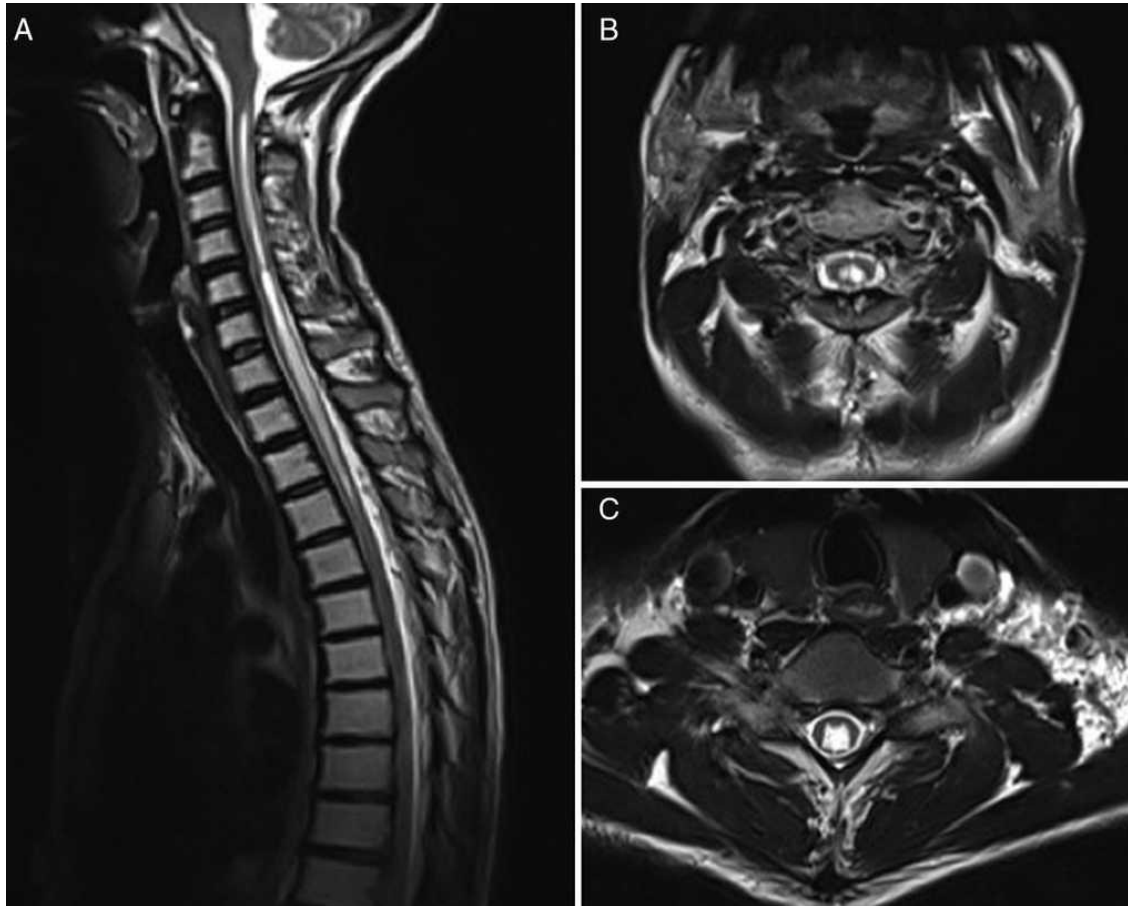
(A) Sagittal T2-weighted MRI sequence of a patient with syringomyelia unrelated to Chiari malformation. (B) Axial T2-weighted MRI sequence at the C2 level. (C) Axial TWI MRI sequence at C6 level
